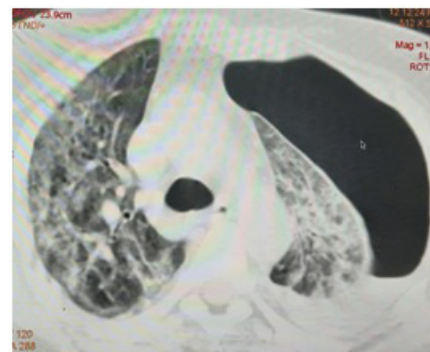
Chest CT findings that confirmed pneumothorax
